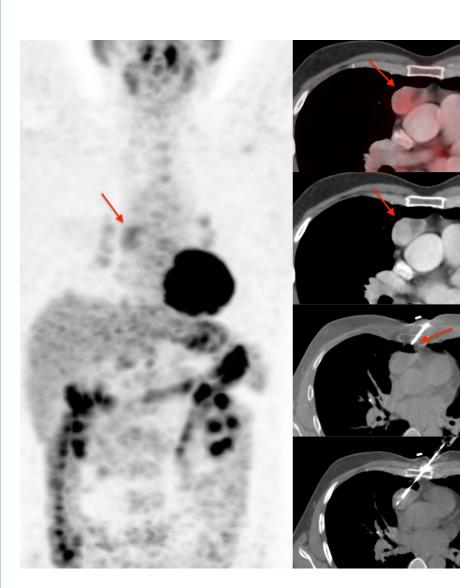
This is a 53-years old man who had an incidentally discovered prevascular space mass. PET/CT showed no other lesion. He came for a biopsy. The only approach was through the lung, so I chose a trans-sternal approach directed along the long axis of the lesion through the lung using a 20G coaxial biopsy gun. A trans-sternal approach is safe and this can be done without sedation, by just infiltrating the periosteum of the anterior cortex. The bone is thin enough that a light tap of the mallet is sufficient to push the needle through. The only disadvantage is the inability to maneuver the needle if needed. The diagnosis was thymoma WHO B type. There was no complication.
